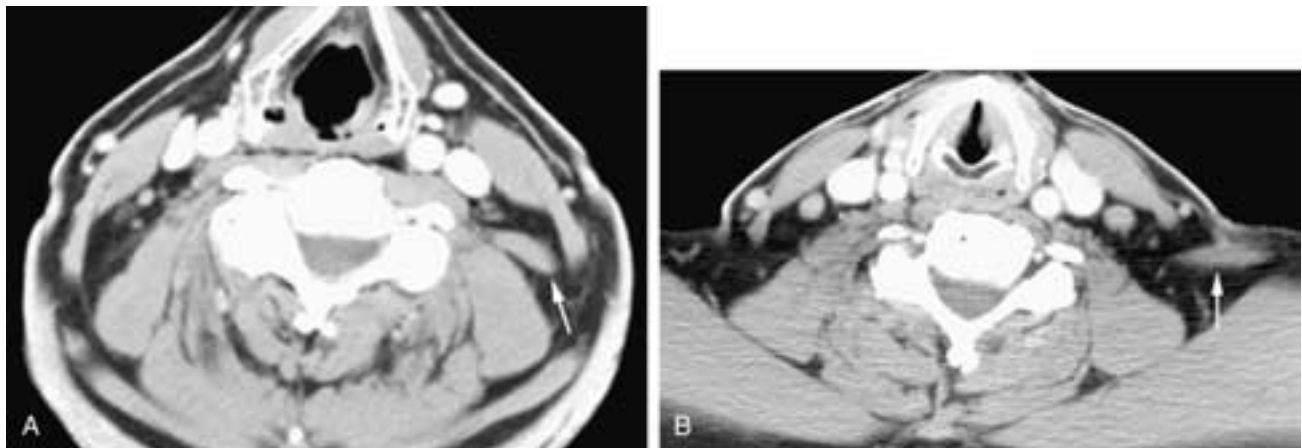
Axial cranial (A) and caudal (B) contrast-enhanced CT scans through the neck show a left-sided levator clavicularae muscle (arrows). The levator lies deep to the sternocleidomastoid muscle in the midneck and lateral to it in the lower neck. (Courtesy of Dr. David Rubinstein.)
